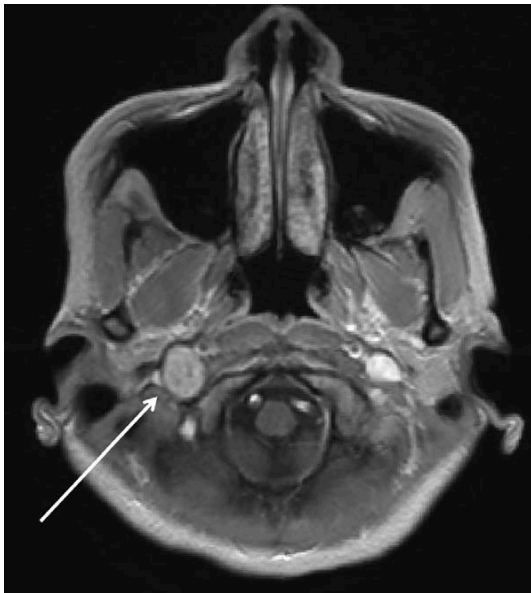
Magnetic resonance imaging (MRI) with arrow showing an approximately 1.0 cm enhancing mass of the jugular foramen consistent with a jugular foramen schwannoma.
